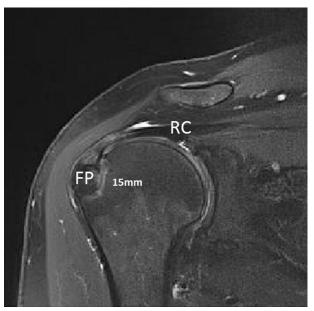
Coronal magnetic resonance imaging scan of patient 2 years postoperatively. Tunnel with a 15-mm bone bridge and recreation of the footprint are clearly appreciated. Sugaya type II tendon. (FP, footprint; RC, rotator cuff.)
